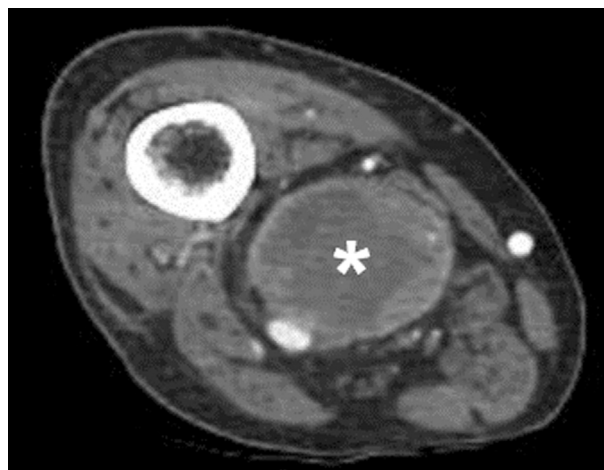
Axial slice of a CT angiography revealing a total thrombosis of the right popliteal aneurysm (asterisk). CT, computed tomography.
